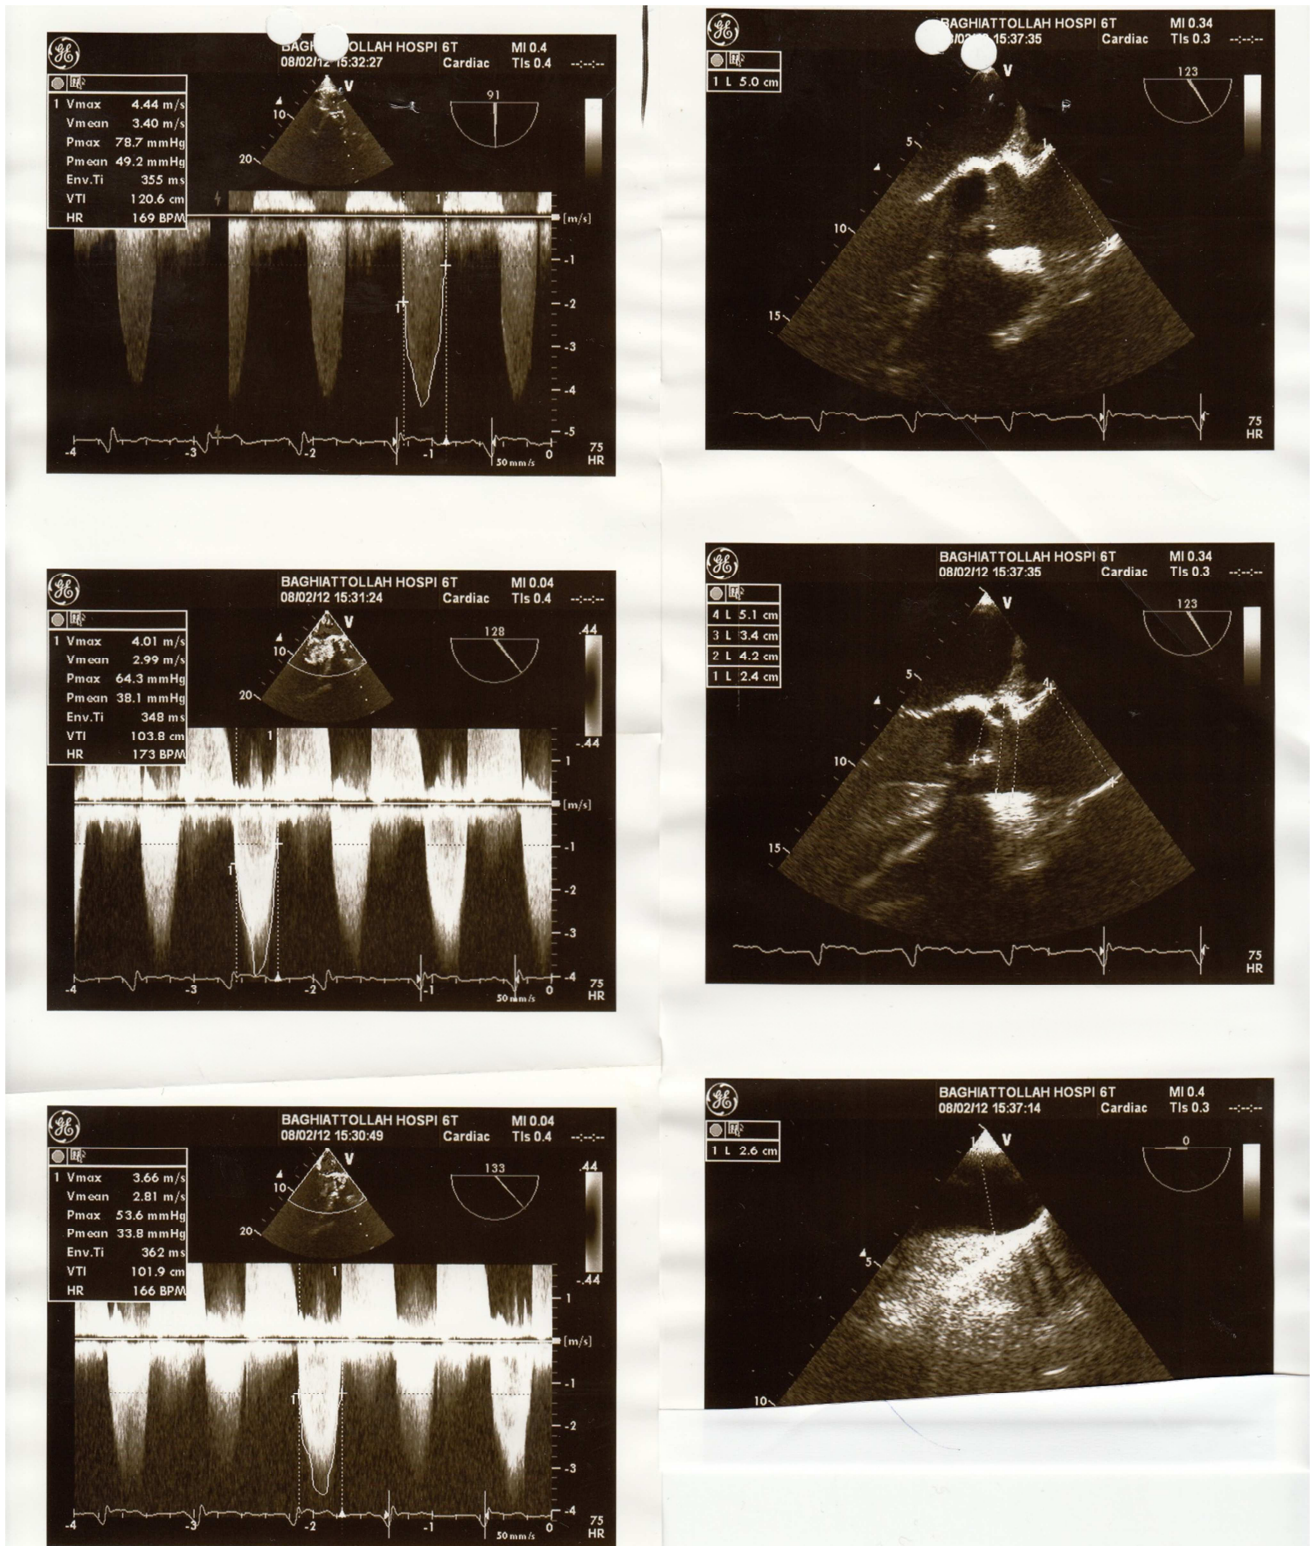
Echocardiography findings at admission (Continue)
